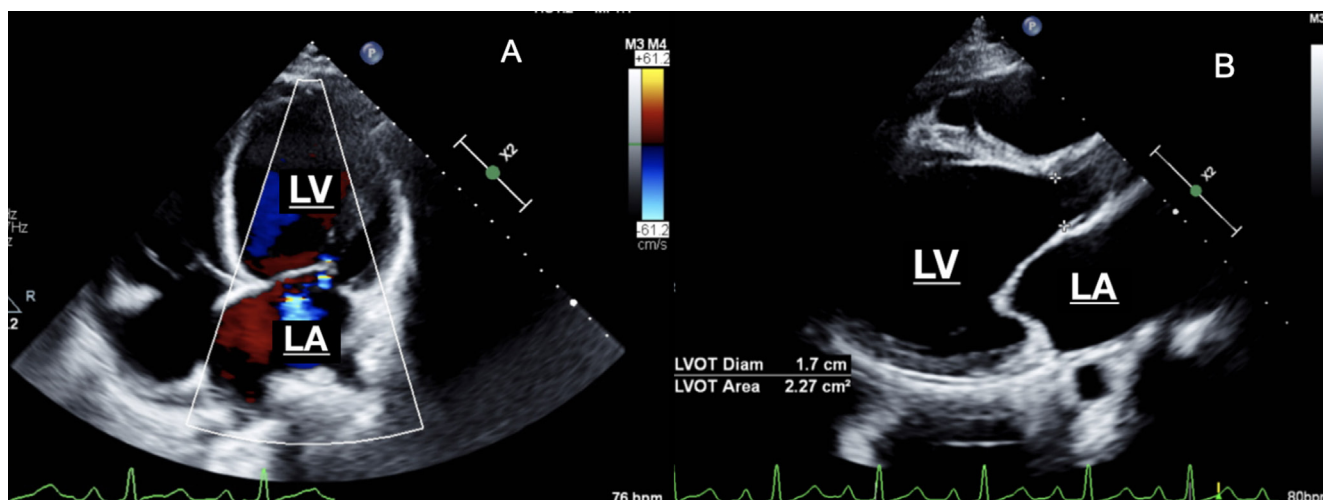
Follow up echocardiogram after 3 months of GDMT, bromocriptine, and life vest use. Parasternal long axis view with no change in comparison to initial view (A). Apical 4-chamber view demonstrating severe LV and LA dilation (B).
